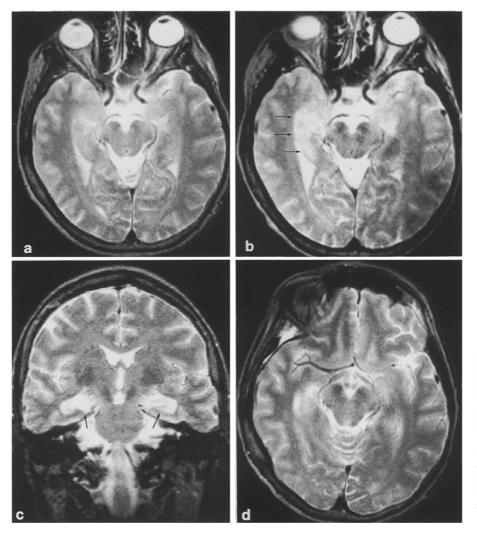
Case 2. Sequential T2-weighted images, SE 2500/90/1. a Both temporal lobes are normal on the initial scan. b Axial MR 16 days later shows abnormal high signal in the right hippocampal formation (arrows). c Coronal MR 5 days later demonstrates symmetrical high signal in both hippocampal formations (arrows). d MR 3 months later shows only subtle high signal in the right hippocampal formation and post-surgical change in the right sphenoid bone. Coronal T2-weighted images were not obtained during that study
